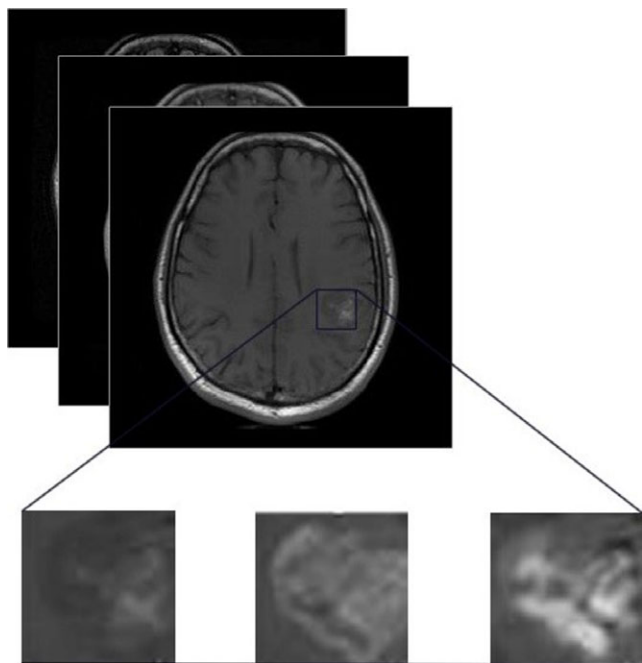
Demonstrating magnified regions in precontrast, postcontrast, and FLAIR sequences, respectively, used to form a three-dimensional input patch representing a tumor. [Color figure can be viewed at wileyonlinelibrary.com]
